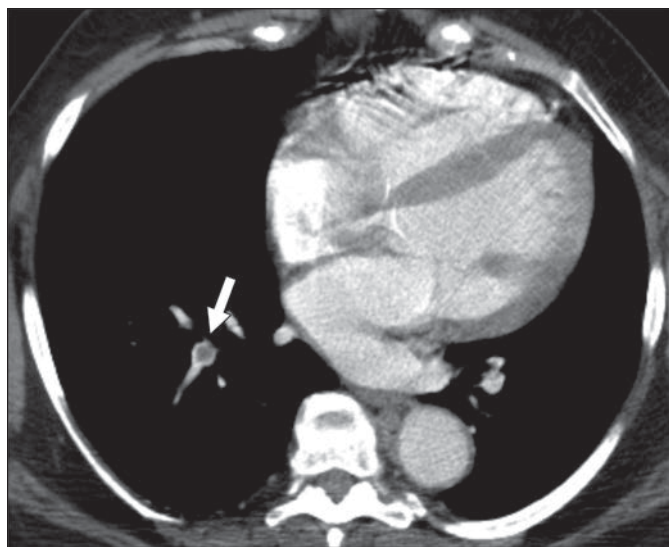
Search error. Abdominal CT scan of 53-year-old man who presented with abdominal pain shows pulmonary embolus (*arrow*) in right lower lobe overlooked on interpretation. Abnormalities of lung bases are commonly missed on abdominal CT because they are not primary target of examination.
